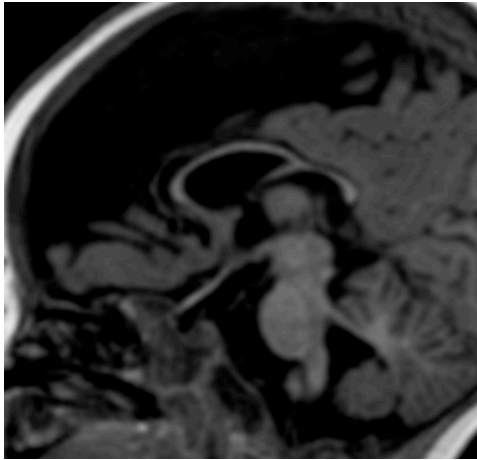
Midline T1 sagittal MRI scan demonstrates upward bowing (convexity) of the corpus callosum in a 6-year-old with hypoxic ischaemic encephalopathy (HIE)
